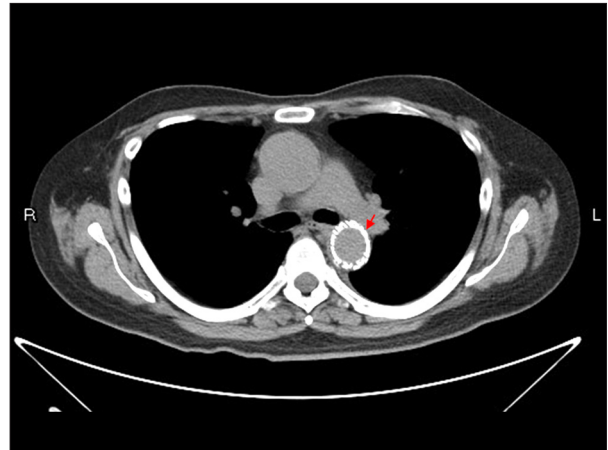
Computed tomography angiogram axial view after transluminal angioplasty to descending aorta.
